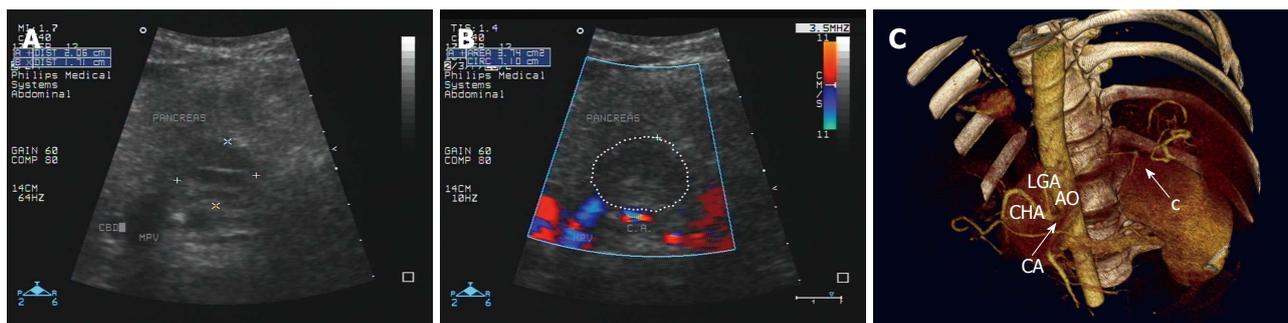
Postoperative imaging. A: Ultrasound showing a 3 cm hypoechoic mass between the proximal splenic artery and the celiac trunk; B: Ultrasound showing no color flow signals in the hypoechoic mass; C: Three-dimensional CT reconstruction revealing the proximal splenic artery without aneurysm recurrence and without collateral vessels supplying the spleen (c). AO: Abdominal aorta; CA: Celiac artery; CHA: Common hepatic artery; LGA: Left gastric artery.
